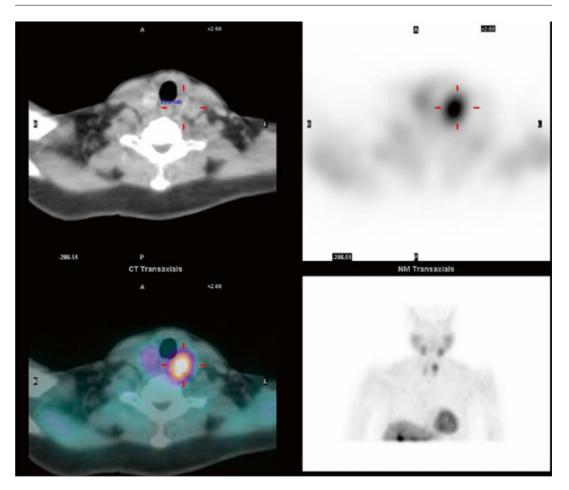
CT/MIBI image of enlarged parathyroid in left upper position
